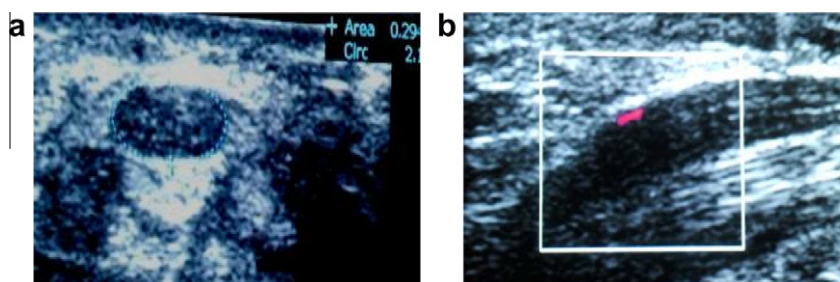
(a) Transverse image of the median nerve at carpal tunnel showed nerve edema and swelling ($CSA = 29 \text{ mm}^2$), as well as bowing of the flexor retinaculum. (b) Power Doppler showed +ve sign of intraneural hypervascularization.
